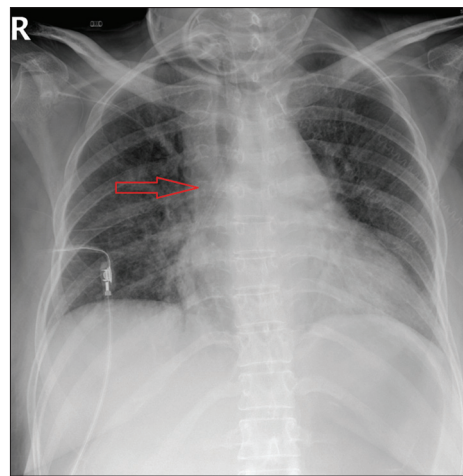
Chest X-ray showing the foreign body in the lower trachea and the right main bronchus where the red arrow is pointing
